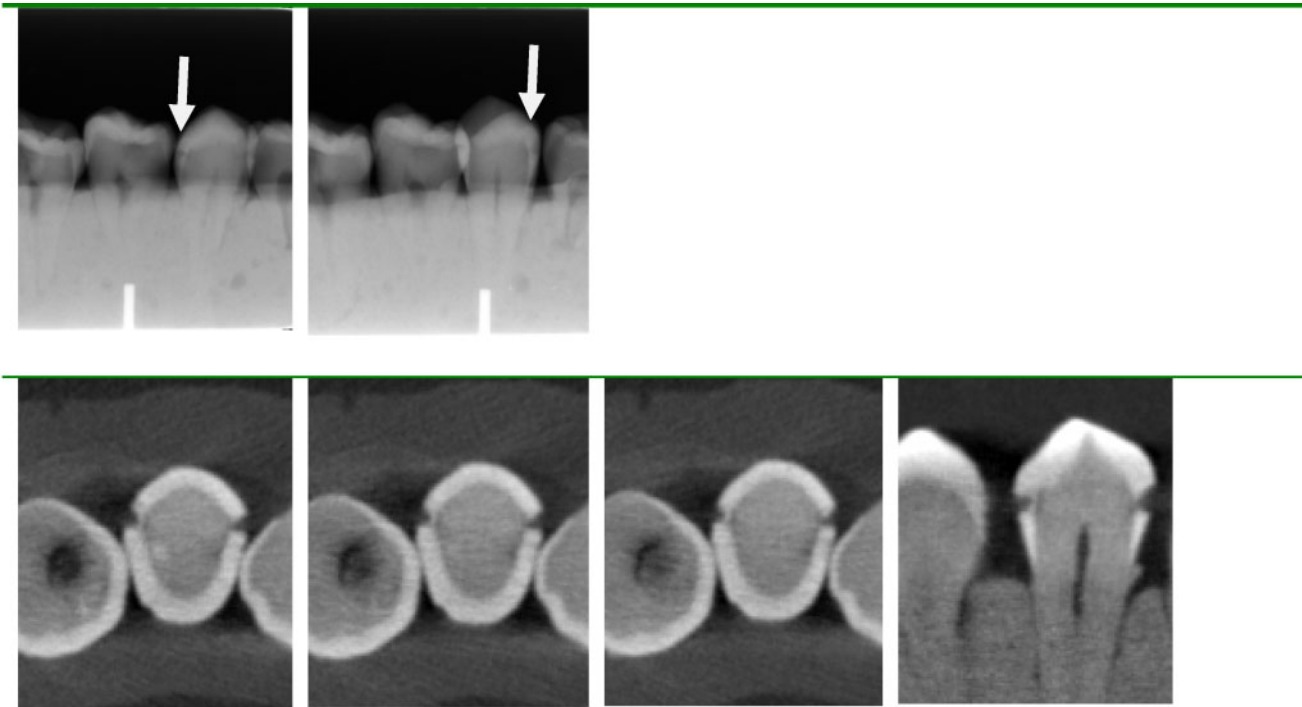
Demineralization just into dentine in both approximal surfaces (arrows) of a premolar scored as non-cavitated in the images from the phosphor plate system (upper row) and scored as cavitated by cone beam CT (lower row)
